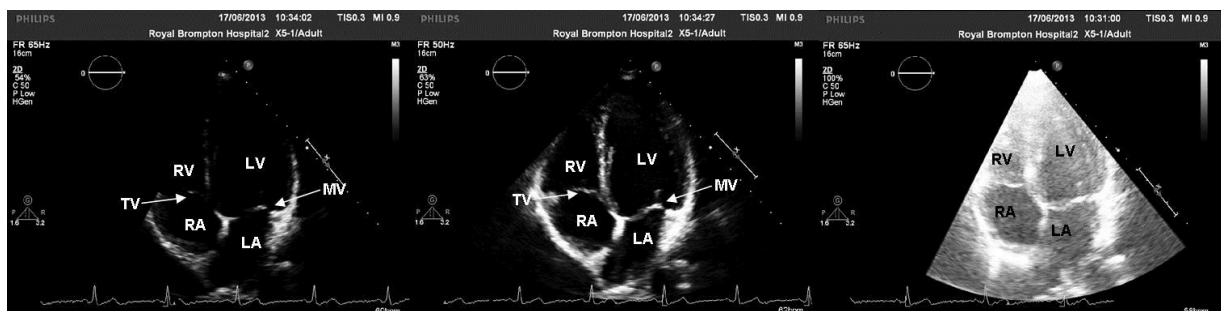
Apical 4-chamber views showing the effect of changing gain on image quality. The central image has optimal gain settings and the cardiac structures (including endocardial border and tricuspid and mitral valves) are visualised clearly. In the image on the left, the gain is too low, the image is dark and the left ventricular walls and tricuspid and mitral valves are not visualised clearly. In the image on the right the gain is too high, resulting in loss of definition of structures.
